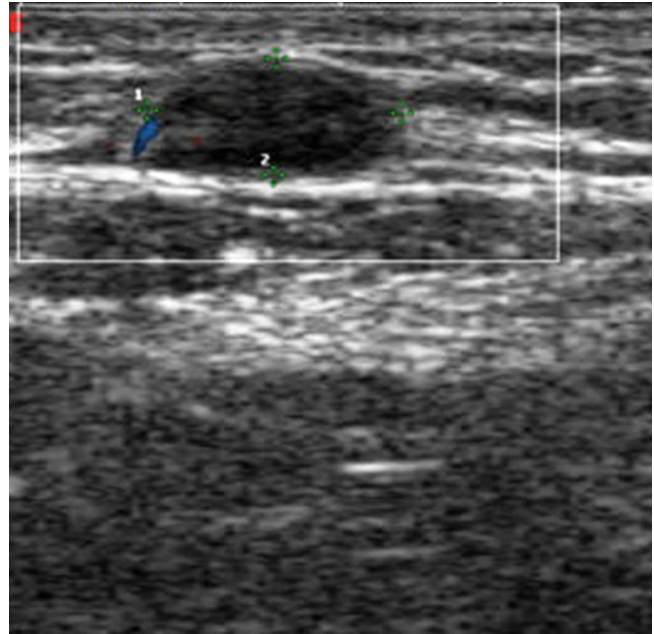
In-transit metastasis. Directional power Doppler image. Small in-transit nodule with slight perfusion at periphery
